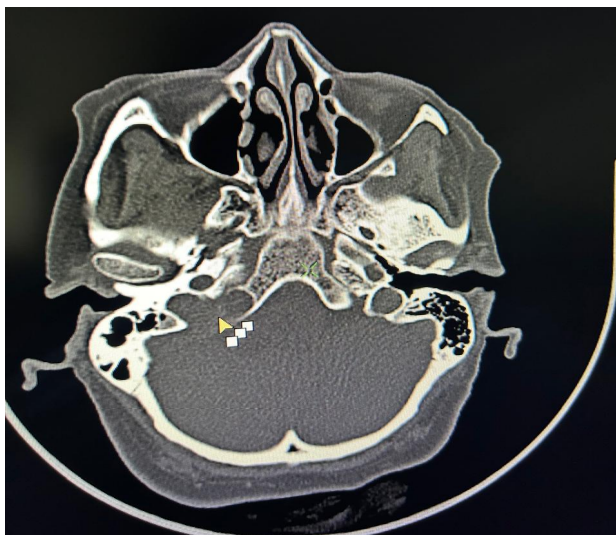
Axial CT scan of the temporal bone at the level of the cerebellopontine angle demonstrating the internal auditory canals and adjacent petrous temporal bone anatomy.
